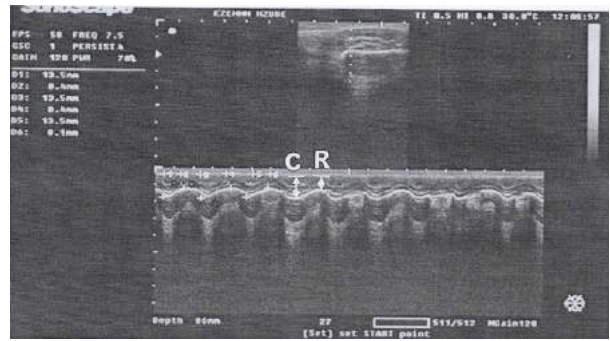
Ultrasound Scan of Masseter Mid Belly in an 8 years old child with digit sucking habit showing contraction (C) and relaxation @.
